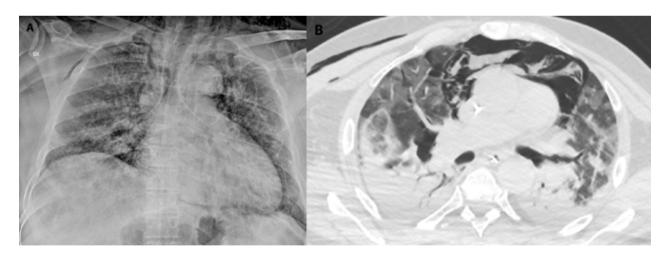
Chest X-ray (A) and CT (B) show pneumomediastinum, pneumothorax and emphysema of soft tissue.
